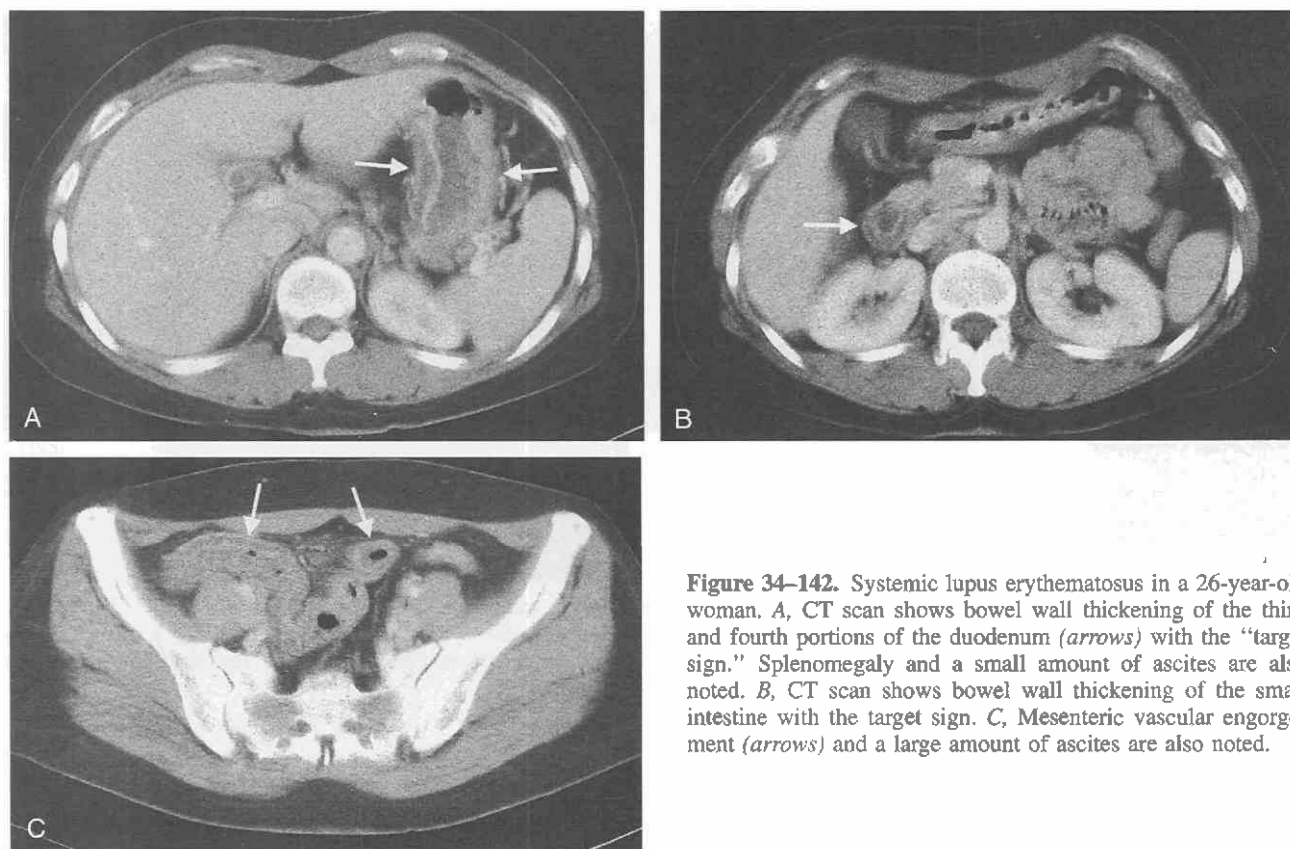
Systemic lupus erythematosus in a 26-year-old woman. A, CT scan shows bowel wall thickening of the third and fourth portions of the duodenum (*arrows*) with the “target sign.” Splenomegaly and a small amount of ascites are also noted. B, CT scan shows bowel wall thickening of the small intestine with the target sign. C, Mesenteric vascular engorgement (*arrows*) and a large amount of ascites are also noted.
